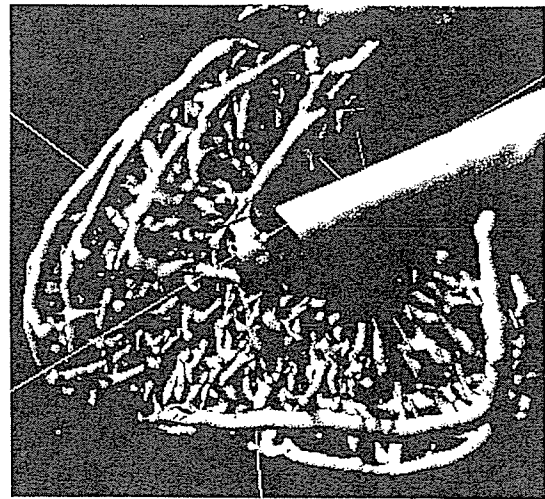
3-dimensional image of coronary arteries constructed from x-ray CT images by Pascal.
